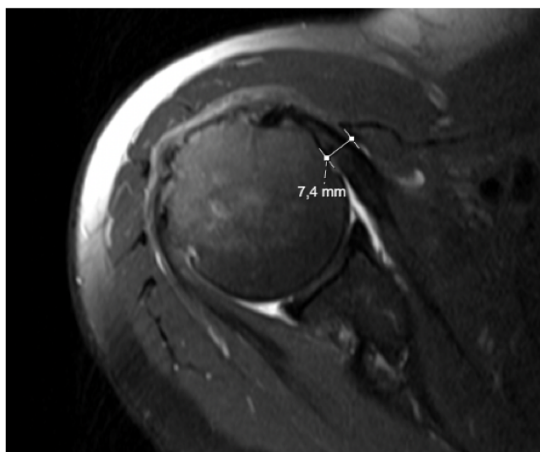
Evaluation of the distance between the humeral head and the coracoid in cross-sectional magnetic resonance imaging (MRI) of the shoulder with subscapular tendinopathy
